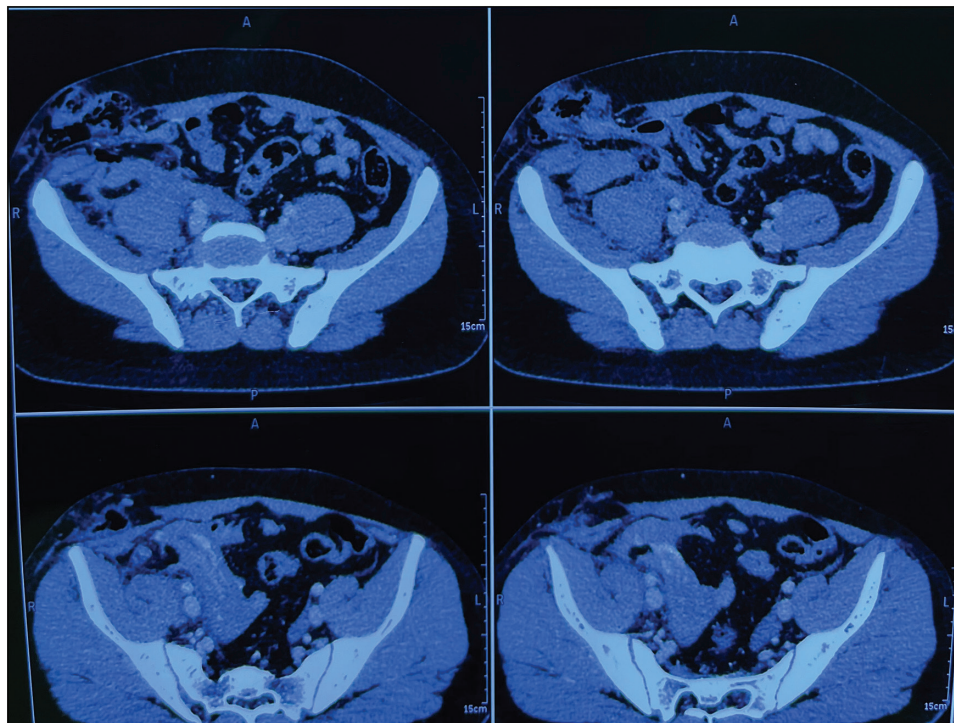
Contrast-enhanced computed tomography picture depicting a defect in the abdominal wall in the right lumbar region with herniation of the bowel
